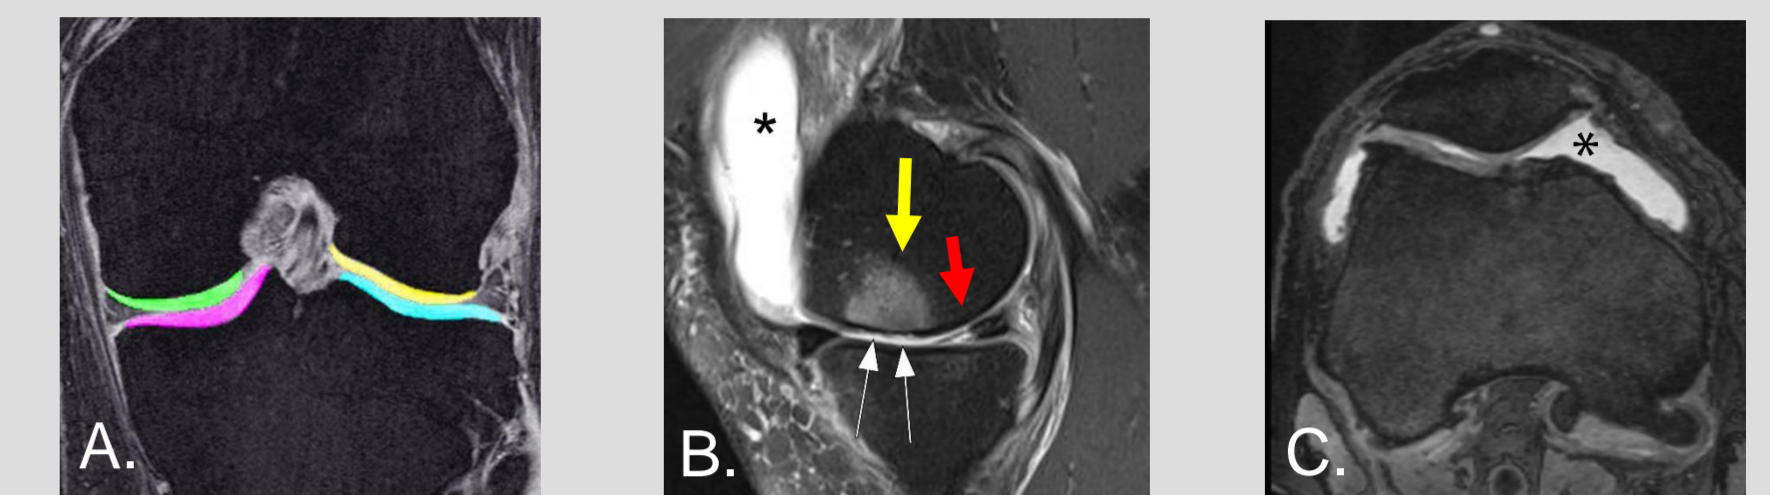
Q and SQ assessment in the FNIH Study. A. Coronal FLASH sequence with water excitation that was used for Q MRI and segmentation. Medial tibial cartilage marked (i.e. segmented) in purple, medial femoral cartilage marked in green, lateral tibial cartilage marked in light blue, and lateral femoral cartilage marked in yellow. B. Sagittal intermediate-weighted fat suppressed sequence shows diffuse cartilage loss at the central femur (white arrows), large femoral BML (yellow arrow) and meniscal maceration (red arrow). In addition, there is marked effusion-synovitis (asterisk) C. Corresponding axial DESS image confirms effusion-synovitis (asterisk).
